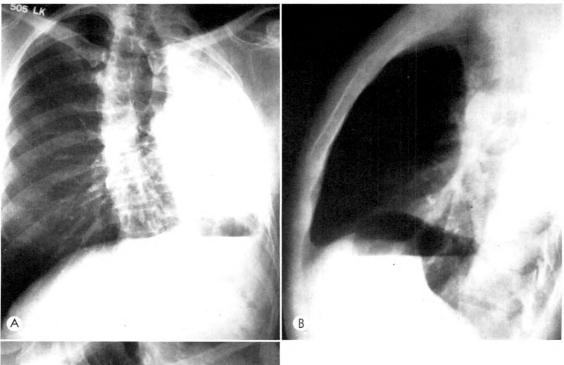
Case II. (A) Frontal teleroentgenogram' of the chest showing a dense left hemithorax, elevated left diaphragm, and marked tracheal and mediastinal herniation into the small left hemithorax. (B) Lateral roentgenogram of the chest demonstrates hyperlucency of the anterior portion of the thorax. (C) Frontal angiocardiogram revealing marked displacement of the superior vena cava, right cardiac chambers, and pulmonary artery into the left hemithorax, assuming the position of the right oblique view. Note the solitary right pulmonary artery which is dilated to supply the right lung which also extends into the summit of the left hemithorax above the cardiac structures.
